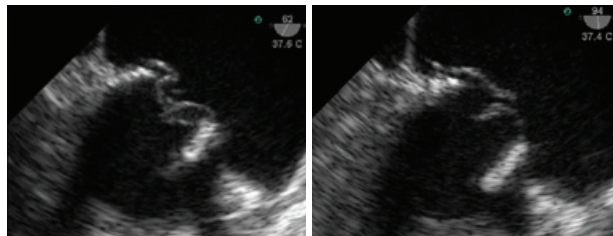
Transesophageal echo showing bioprosthesis coaptation deficit with eversion and flail of one leaflet over the opposing one, and prolapse of a deformed leaflet (90° view).
